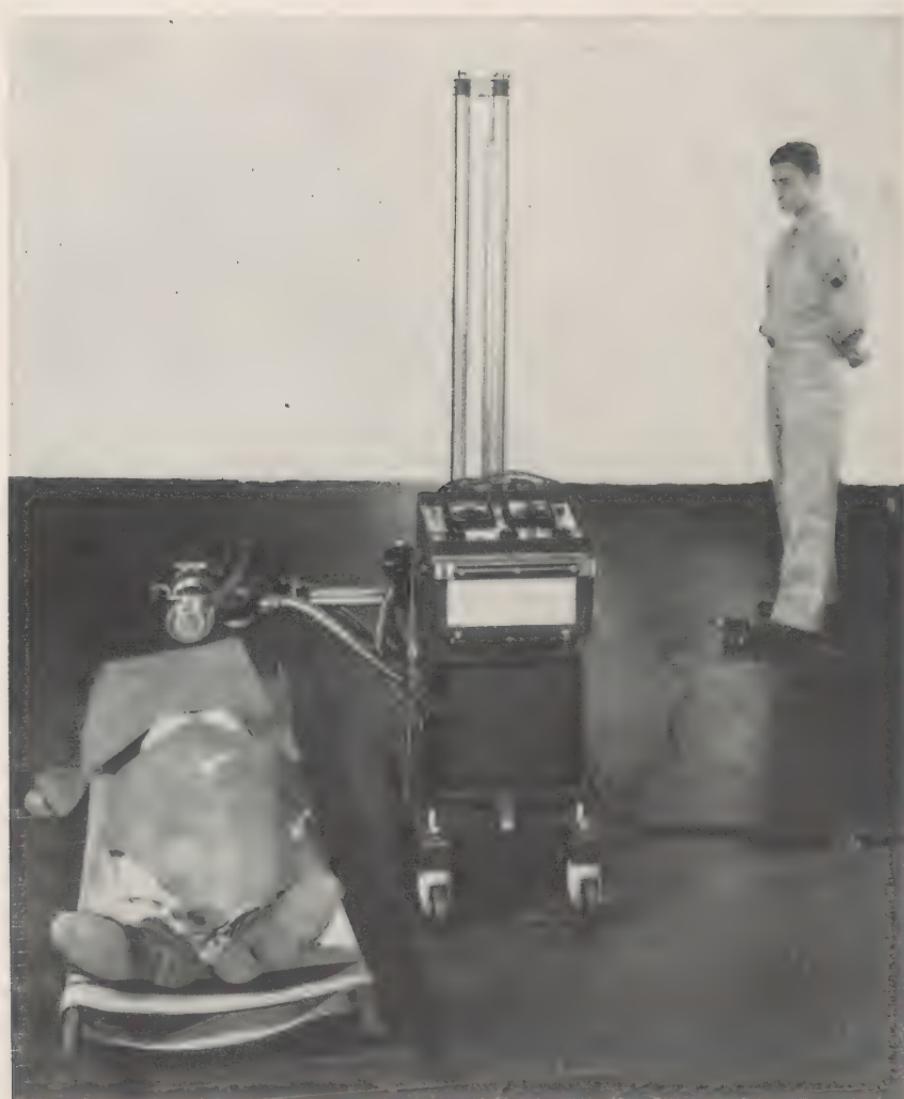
Roentgenotherapy as administered in the field. (Note protection given patient, except for limited areas where X-radiation is desired. Also note that protection to operator is accorded mainly by distance and his precautions as to positioning the X-ray tube properly.)
